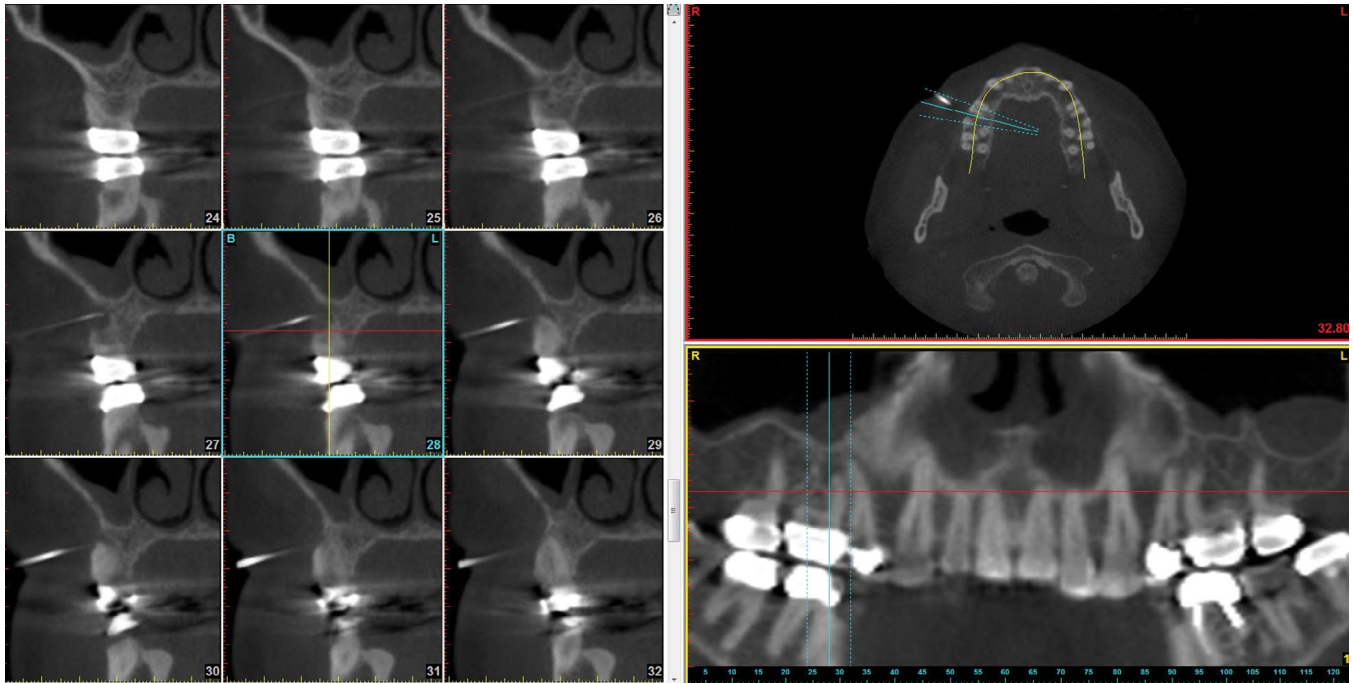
Gutta-percha points to maxillary first molar that has a periapical radiolucency indicating need for endodontic therapy secondary to a necrotic pulp that has caused an infected granuloma.
